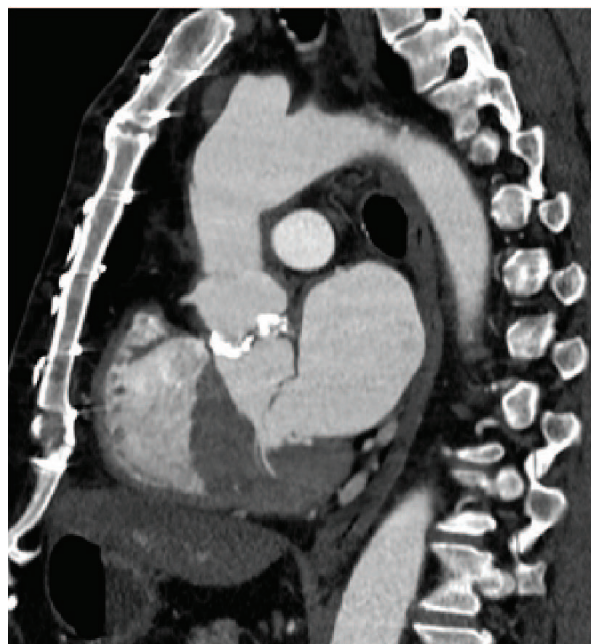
Preoperative computed tomography shows a significantly calcified aortic valve.
